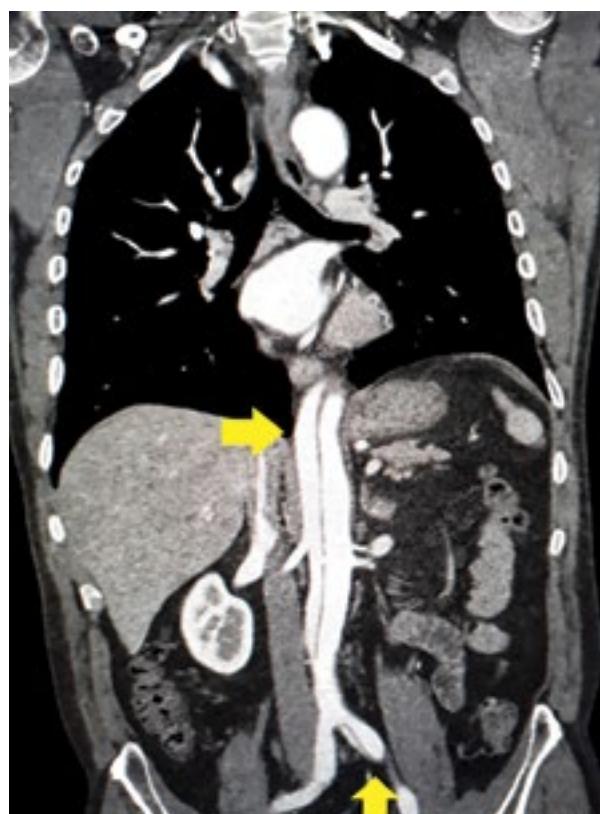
Computed tomography (CT) scan: dissection of the aortic wall from the level of the descending aorta to the bifurcation and common iliac artery (CIA)
